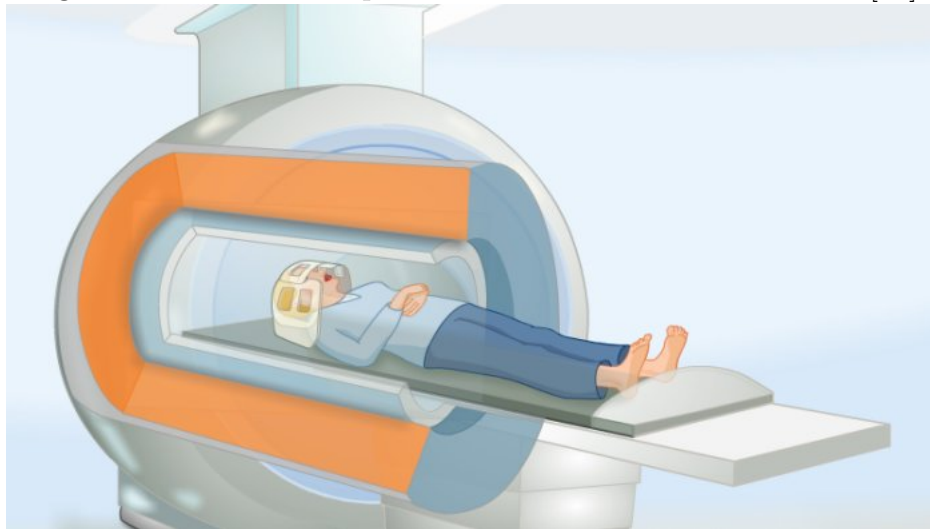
Representation of a modern MRI scanner [83]
